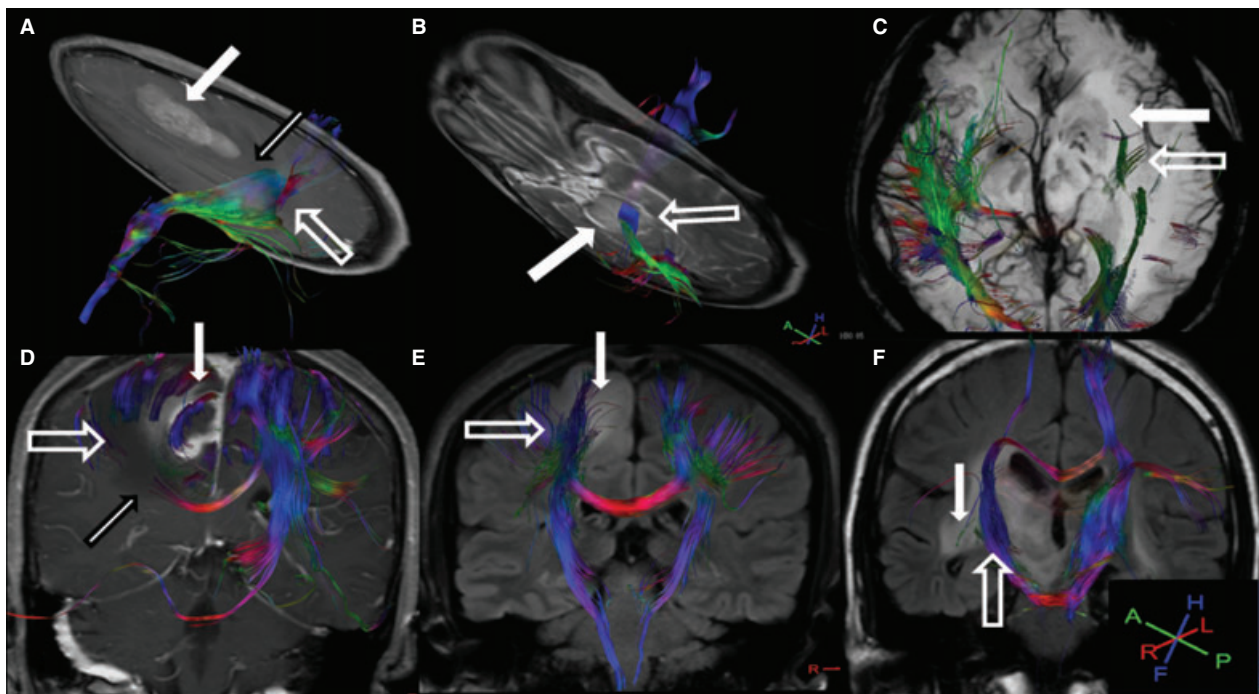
The potential patterns of the white matter fiber tracts were altered by cerebral neoplasms. (A) Axial T1W with contrast enhancement shows that the ipsilateral corticospinal tract (hollow arrow) was displaced posteriorly by the anaplastic meningioma (WHO III) (white arrow) and vasogenic edema surrounding the tumor (black edge arrow) in the left frontal lobe. The fractional anisotropy in the ipsilateral corticospinal tract was reduced 15.8% compared with the contralateral tract. (B) Axial T1W with contrast enhancement shows that the left corticospinal tract (hollow arrow) was displaced by the astrocytoma (WHO II) (white arrow) in the pons. (C) Axial three-dimensional FFE Venous BOLD shows that the ipsilateral inferior longitudinal fasciculus (hollow arrow) was disrupted by the astrocytoma (WHO III) (white arrow) in the left temporal and insula lobe. (D) Coronal FLAIR shows that the ipsilateral corticospinal tracts and superior longitudinal fasciculus (hollow arrow) were disrupted by the astrocytoma (WHO III) (white arrow) in the right parietal lobe. The splenium of the corpus callosum was interrupted (black edge arrow), and the tract in the peritumoral edema was affected. (E) Coronal FLAIR shows that the ipsilateral corticospinal tracts (hollow arrow) were inside the oligoastrocytoma (WHO II) (white arrow) within the right parietal lobe. (F) Coronal FLAIR shows that the ipsilateral corticospinal tract (hollow arrow) was inside the germinoma (white arrow) within the right basal ganglia through the internal capsule and into the cerebral peduncle.
